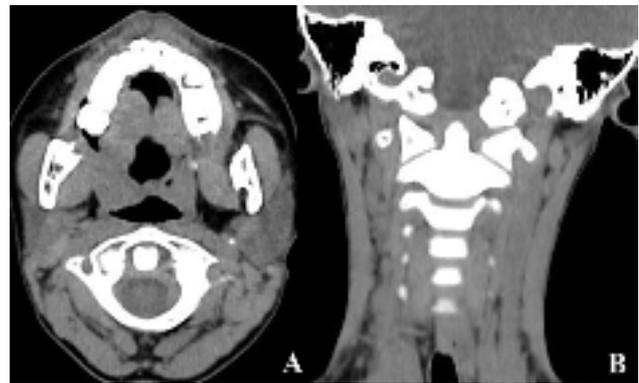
A. Axial, B. Coronal reconstructed cervical CT scan demonstrating the normal alignment of the atlantoaxial complex after collar therapy.
